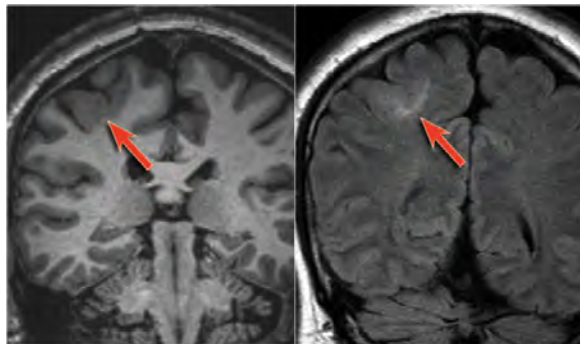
T1w MRI (left) shows cortical thickening and GM-WM blurring, while FLAIR (right) reveals matching subcortical hyperintensity, typical of FCD Type II (photo: © RadiologyAssistant.nl, educational reuse).
